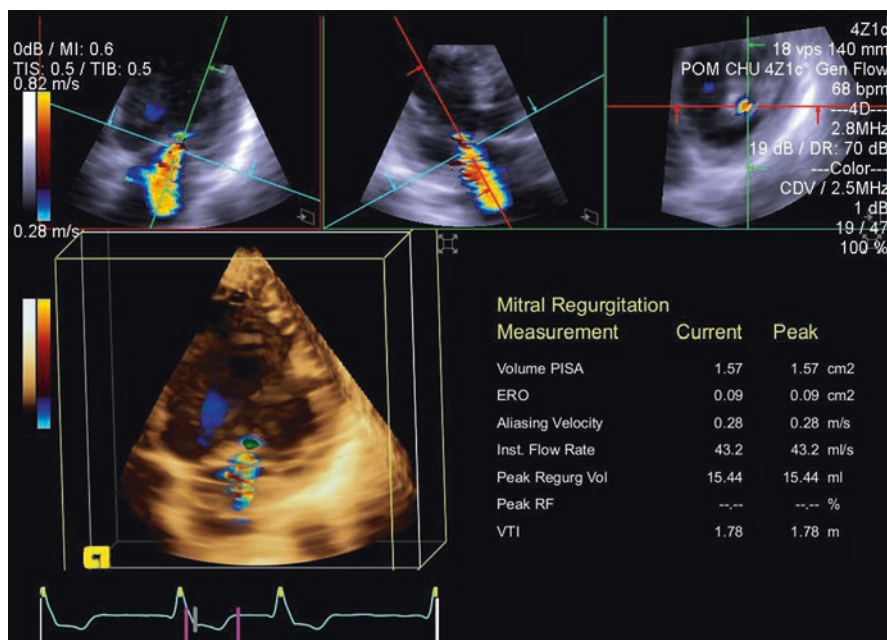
Some of the pitfalls in assessment of secondary mitral regurgitation severity are summarized in this figure. Upper panel depicts the limitations of proximal isovelocity surface area method that tend to underestimate the secondary mitral regurgitation severity (decrease in PISA radius at mid-systole as shown by the colour flow Doppler M-mode assessment and the fact that the flow convergence has an elliptical shape, not hemispherical as assumed by the PISA method). Lower panel shows, with the help of 3D echocardiography, the fact that the regurgitant orifice is dynamic during systole with the smallest regurgitant orifice in mid-systole and the largest at early and late-systole. This phenomenon leads to a systematic underestimation of secondary mitral regurgitation
